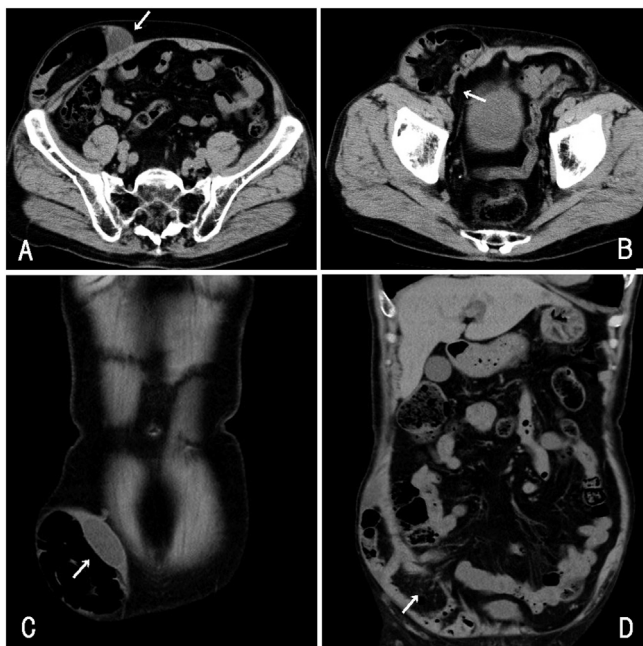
Computed Tomography (CT) scan findings.
